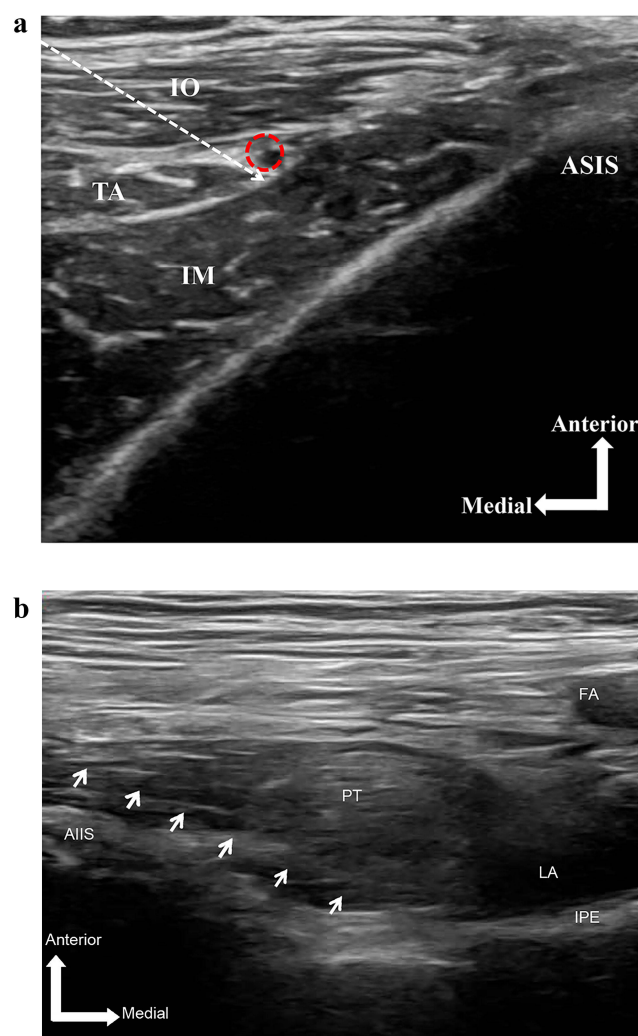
(a) Ultrasound image for identification of the relevant structures for modified suprainguinal fascia iliaca block (modified S-FICB). The needle tip was located under the fascia iliaca between the deep iliac circumflex artery and iliac muscle. Dashed arrow, needle pathway; red area circled by dashed line, deep iliac circumflex artery. (b) Images of ultrasound-guided pericapsular nerve group (PENG) block. The needle tip was positioned between the psoas tendon and the pubic ramus using an in-plane approach. The needle is outlined by the arrows; arrow, needle pathway.
